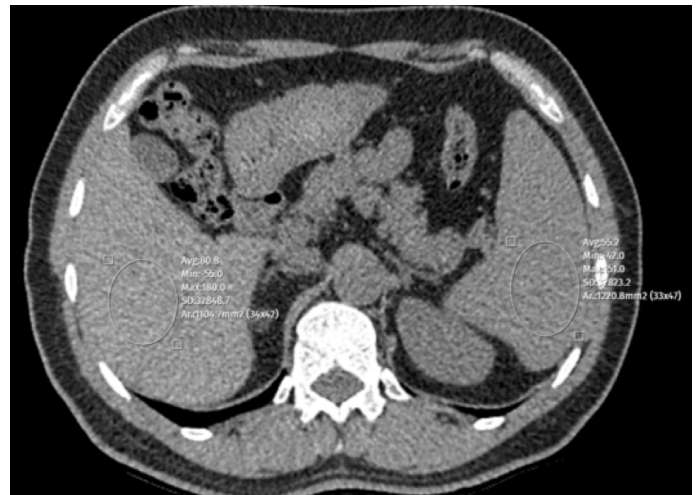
Density measurement in liver and spleen parenchyma in axial image on non-contrast abdominal CT.
